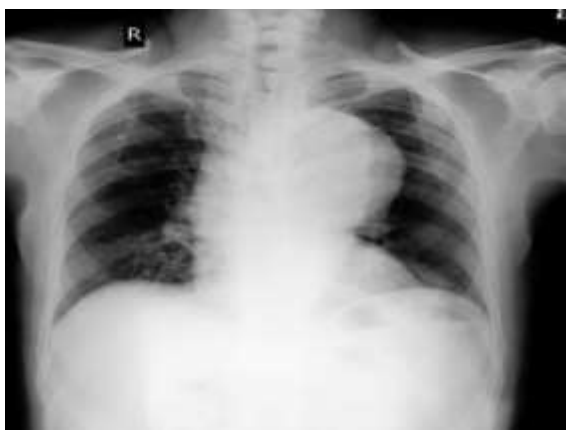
X-Ray Chest PA view showing anterior mediastinal mass on left side
